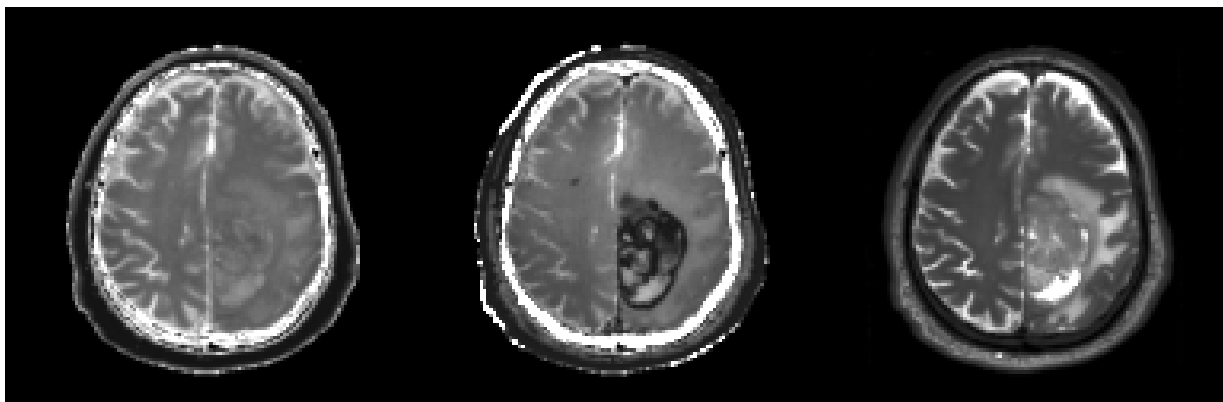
Example of normalized version of T1-weighted image, T1-weighted image with contrast agent and T2-weighted image (from right to left).
